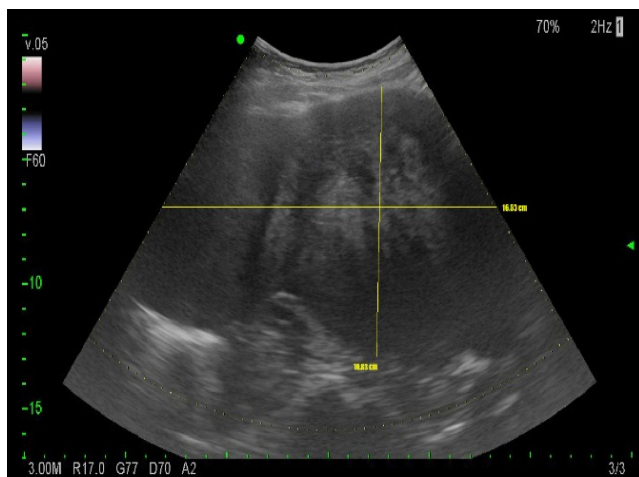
The ultrasonography revealed huge heterogenous pelvic mass.
